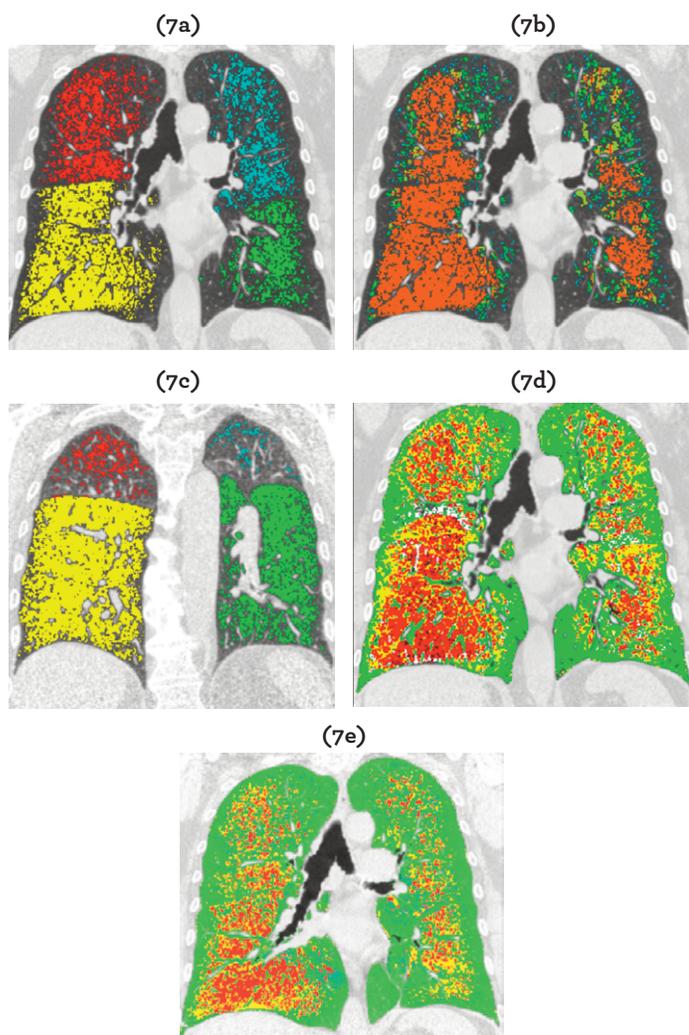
Followup CT Analysis in Same Subject as Shown in Figure 6. Color coding: Same as in Figure 6. (a) % LAA-950 has increased from 14% to 23%. (b) Cluster sizes have also increased. (c) Air trapping appears to have increased from 38% to 45%. (d) Inspiratory-expiratory registration shows that only the amount of emphysema increased, while the amount of gas trapping remained constant. (e) Longitudinal registration of baseline and followup inspiratory scans with micromapping shows areas of stable emphysema in red, new areas of emphysema in yellow, and stable normal lung in green. Images courtesy of Eva van Rikxoort, PhD, Radboud University Nijmegen Medical Centre.
